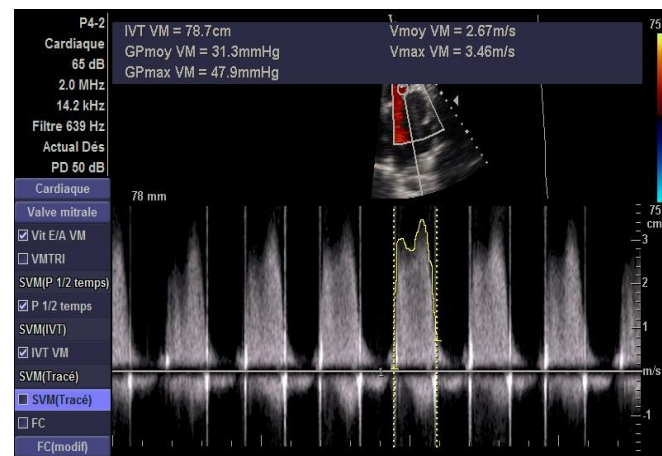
Continuous Doppler over the mitral valve with a mean trans-valvular gradient of 31.3 mmHg.
